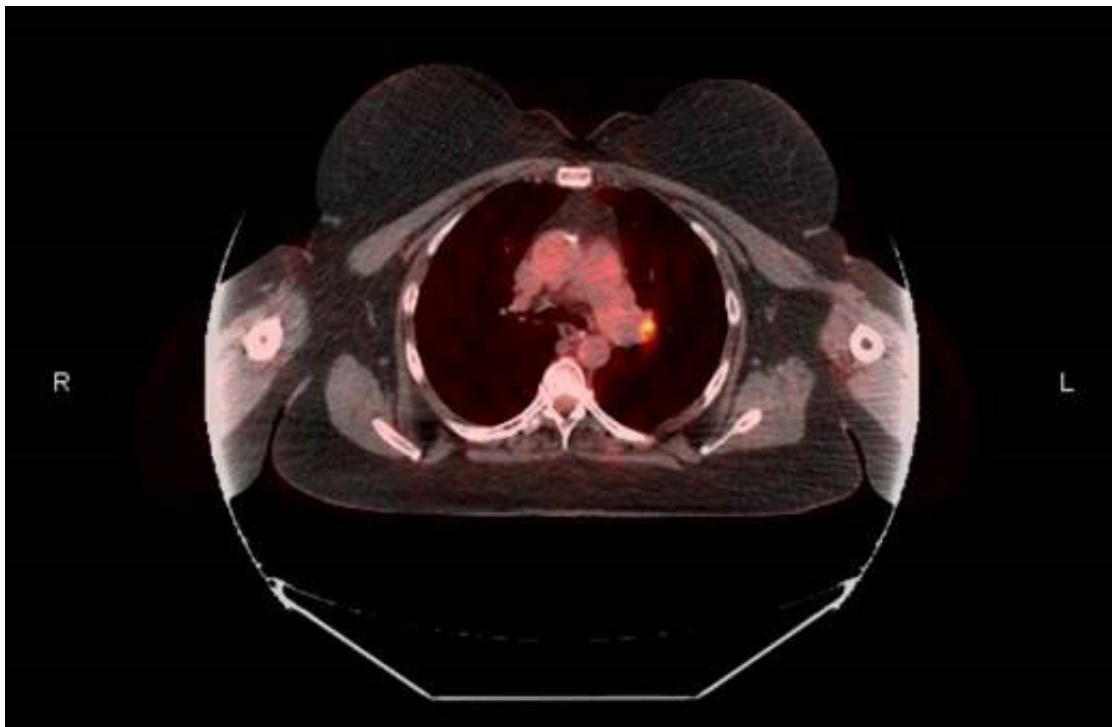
PET-CT of mid-lung. The scan revealed a nodular density measuring approximately 10 x 9 cm at the left hilum, consistent with a borderline-enlarged left hilar lymph node. PET-CT, positron emission tomographic computed tomography.
